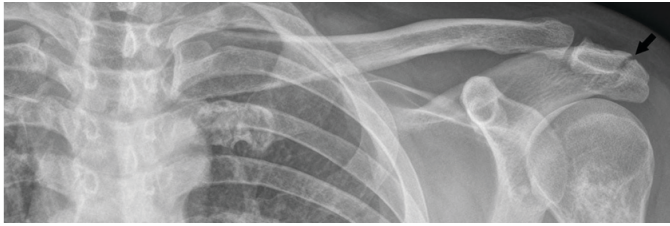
AP X-ray of acute minimally displaced fracture of the left acromion.
